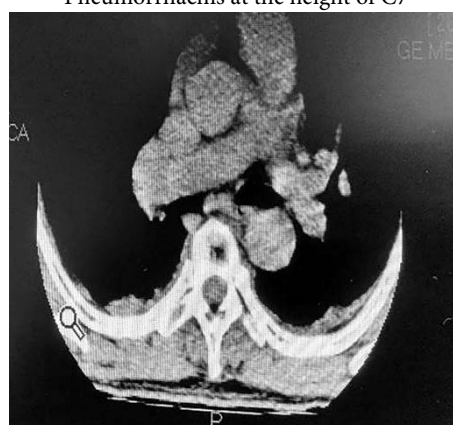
Dorsal spine CT scan showing evidence of Pneumorrhachis at T5
